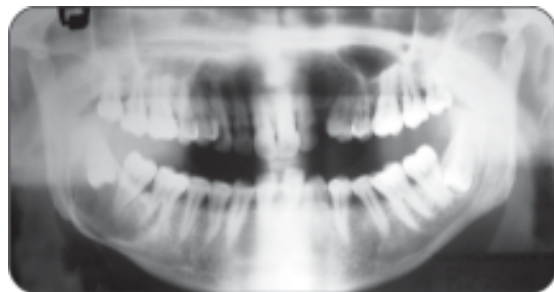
Radiograph of dentigerous cyst
